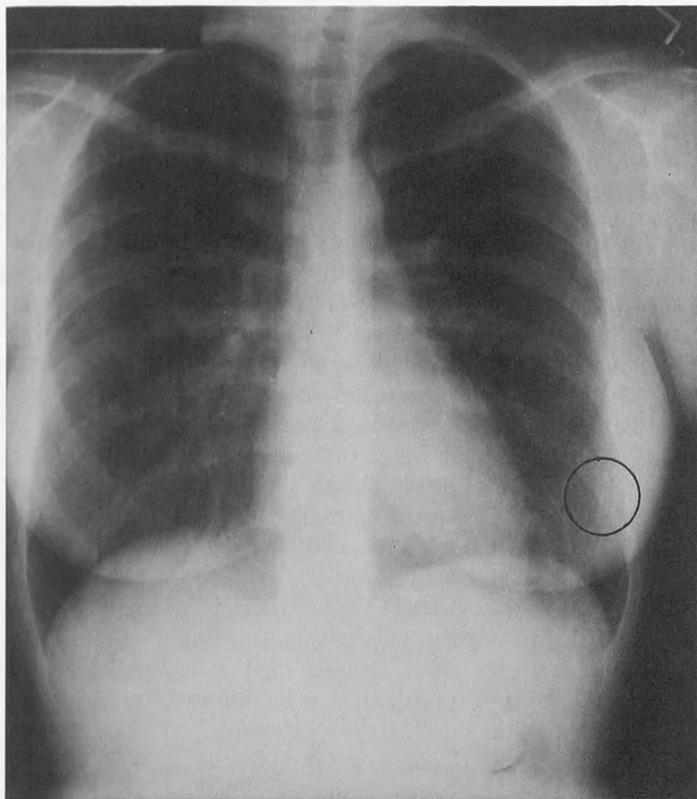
Follow-up chest x-ray film taken 4 months after the previous film revealed callus formation on the eighth rib at the location of the stress fracture.
